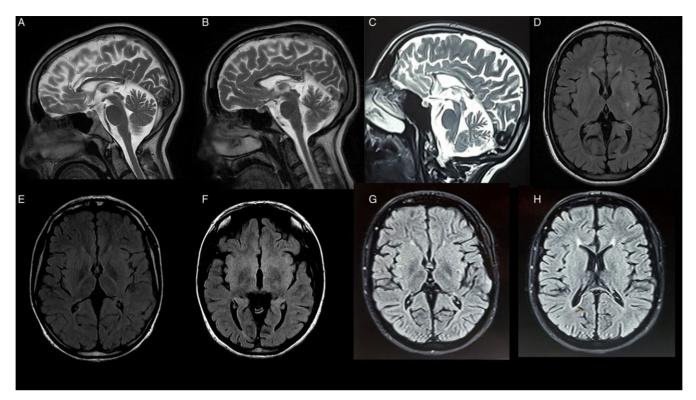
Brain MRI of cases II3 (A, D, E), II8 (B, F) and II9 (C, G, H) shows thin corpus callosum on sagittal T2 sequences (A, B, C), white matter hyperintensity around the frontal horns on FLAIR sequences (D, H) and normal basal ganglia (no evidence of iron accumulation) (E, F, G).
